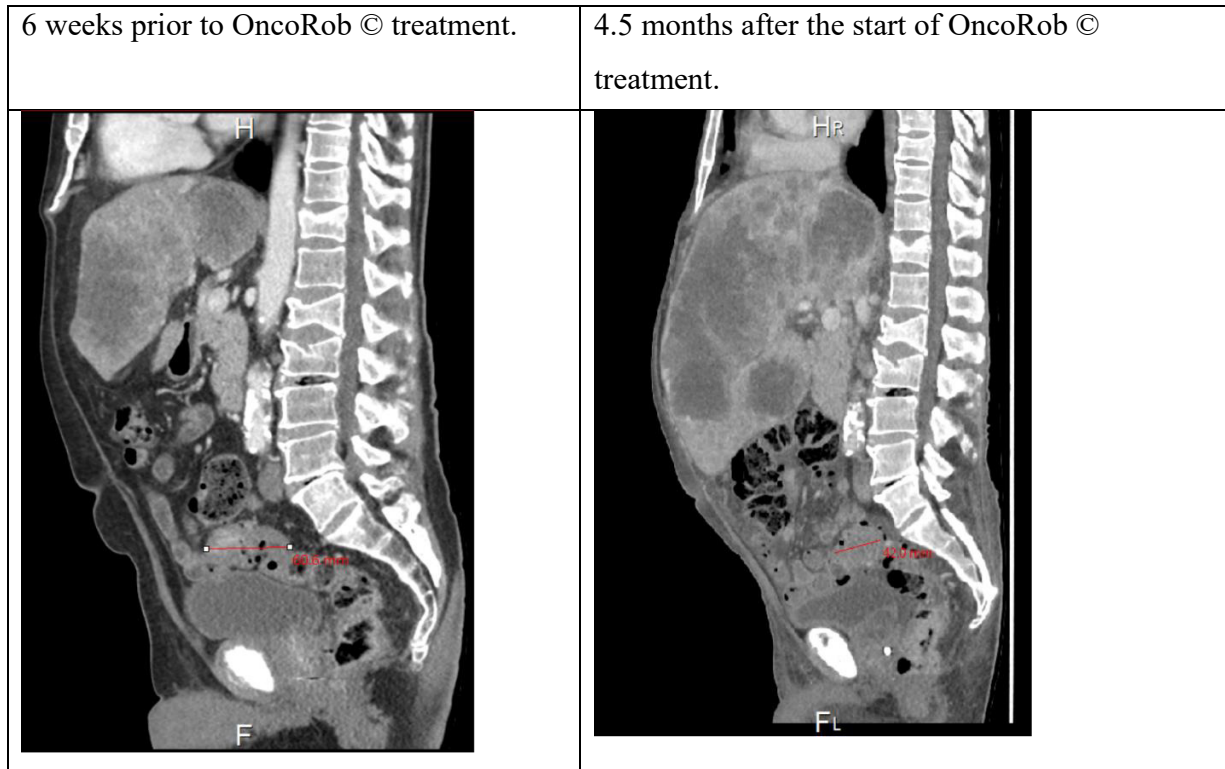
Sigmoid and Prostate Patients’s CT Scan Images Pre and Post OncoRob © Treatment
